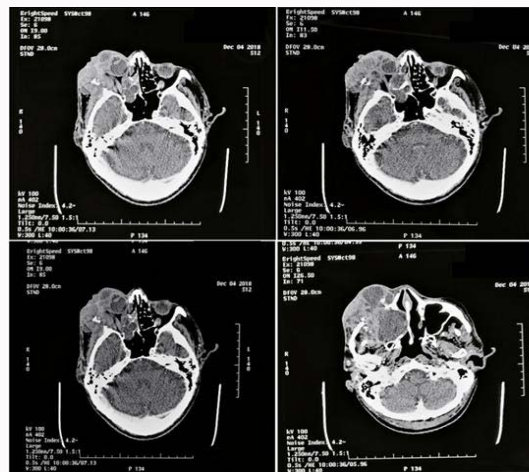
The CT scan shows a locally invasive latero-orbital tumor process.
